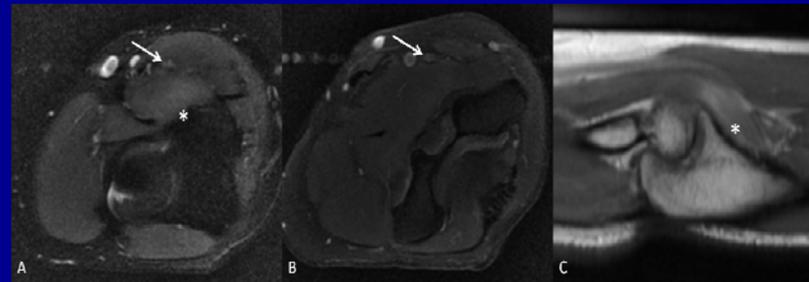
Magnetic resonance imaging of a patient with brachialis syndrome. A: T2-weighted, axial view of the distal arm demonstrating increased signal and enlargement of the median nerve (arrow). There is increased signal and enlargement of the brachialis muscle consistent with edema. B: T1-weighted sagittal view of the distal arm demonstrating increased signal in the brachialis muscle as it is tented over the coronoid process in extension.
